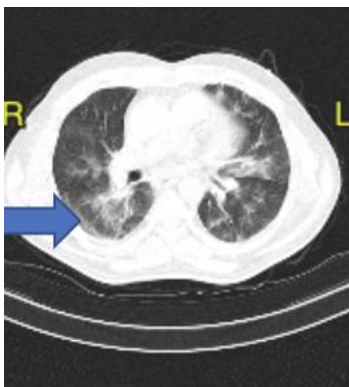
Showing Ground Glass Opacity on HRCT Chest
